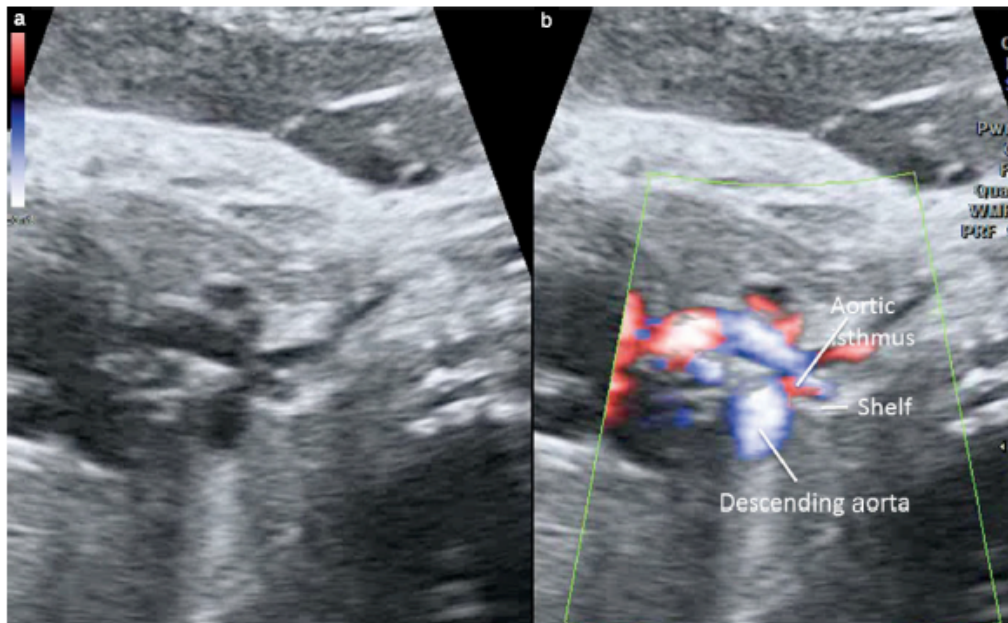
Sagittal view of the aortic arch in a fetus showing a posterior shelf on two-dimensional ultrasound (a) and color flow mapping (b).
